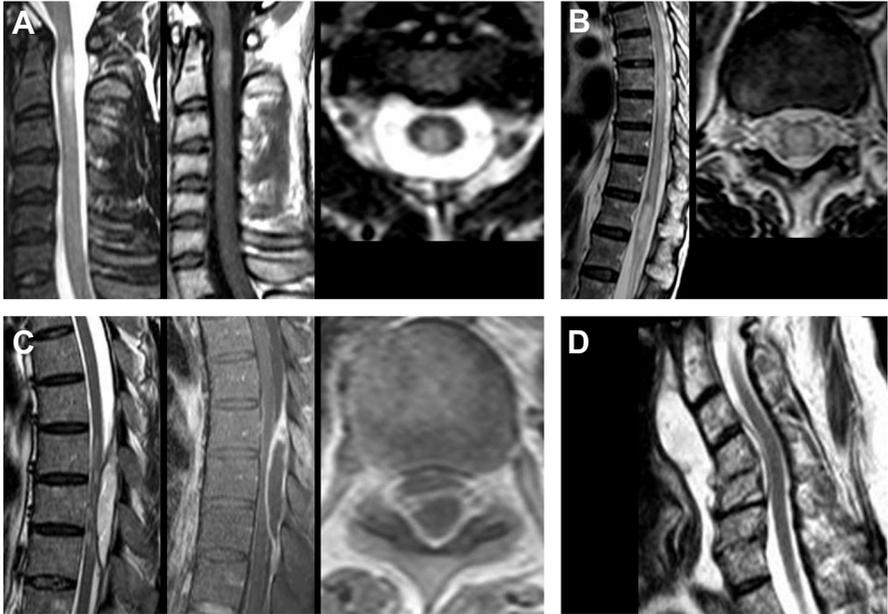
MRI of acute myelopathies. (A) Myelitis isolated to the posterior aspect of the upper cervical cord; (B) Dural arterio-venous fistula with extensive longitudinal lesions of the thoracic cord and conus medullaris; (C) Epidural abscess resulting in posterior compression of the thoracic cord; (D) Spondylodiscitis resulting in posterior dislocation of the middle thoracic cord.¹⁸ (From Stasolla A, Prosperini L, Haggiag S, et al. Non-traumatic acute myelopathies: Clinical and imaging features in a real world emergency setting. *Neuroradiol J.* 2022;35(6):727–35. <https://doi.org/10.1177/19714009221096823>.)
